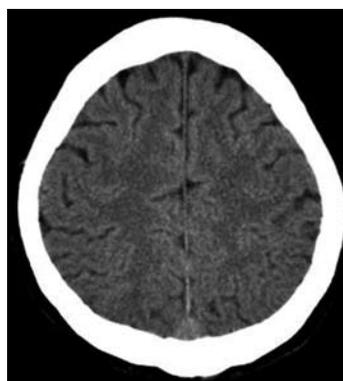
A follow-up head CT obtained 5 wk after the second TACE showed no abnormality and the previously observed lipiodol deposition cleared entirely.
